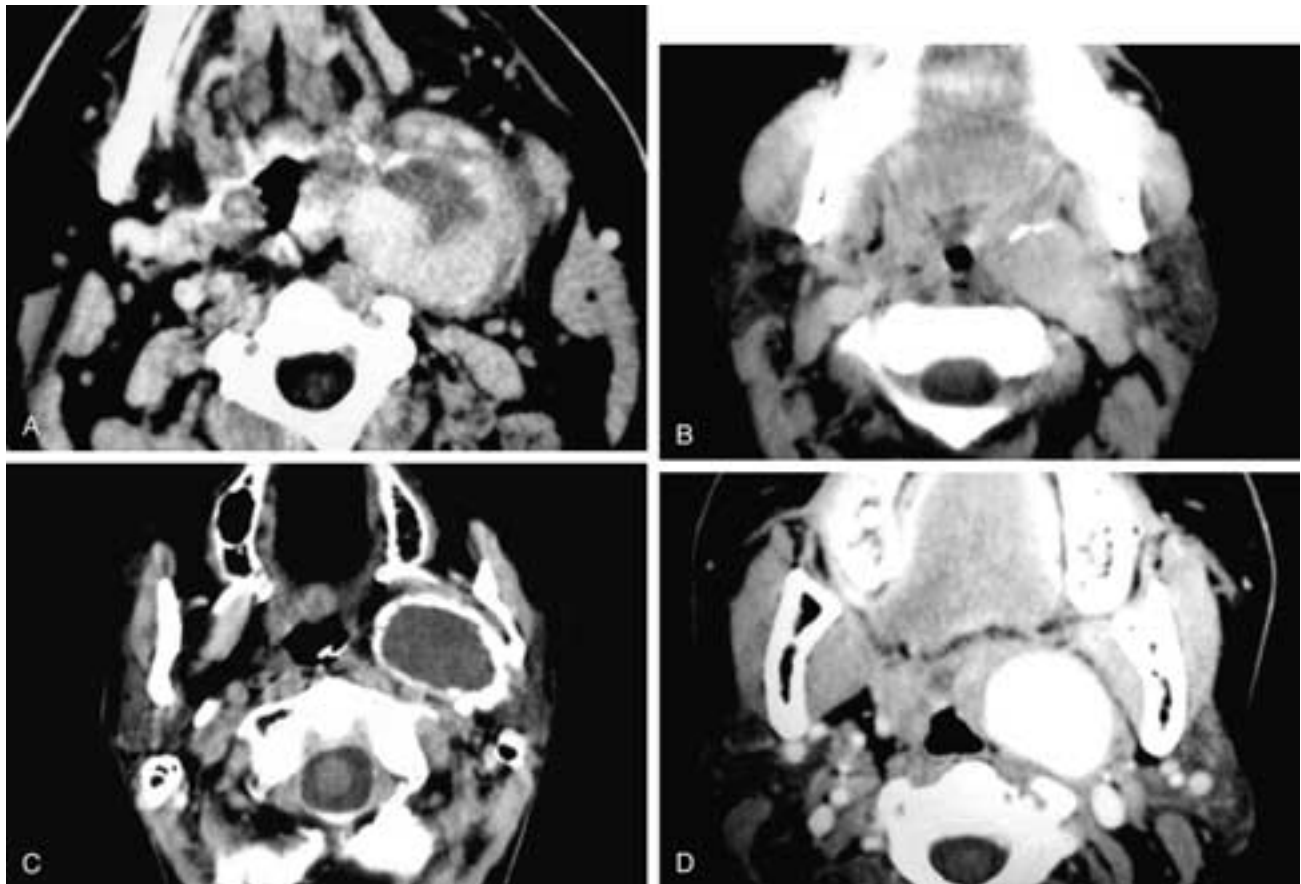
Axial contrast-enhanced CT scan (A) shows an ovoid, partially enhancing mass with peripheral calcifications in the left parapharyngeal space. The ICA could not be identified. This was an aneurysm of the ICA. Axial contrast-enhanced CT scan (B) shows an oblong enhancing mass with peripheral calcification in the left parapharyngeal space. The ICA could not be identified. This was an aneurysm of the ICA. Axial CT scan (C) shows an ovoid water attenuation mass in the left parapharyngeal space with peripheral calcification. Compare this aneurysm of the ICA with that in Figure 38-11B. Axial contrast-enhanced CT scan (D) shows a large, spherical, enhancing mass in the left parapharyngeal space replacing the left ICA.
